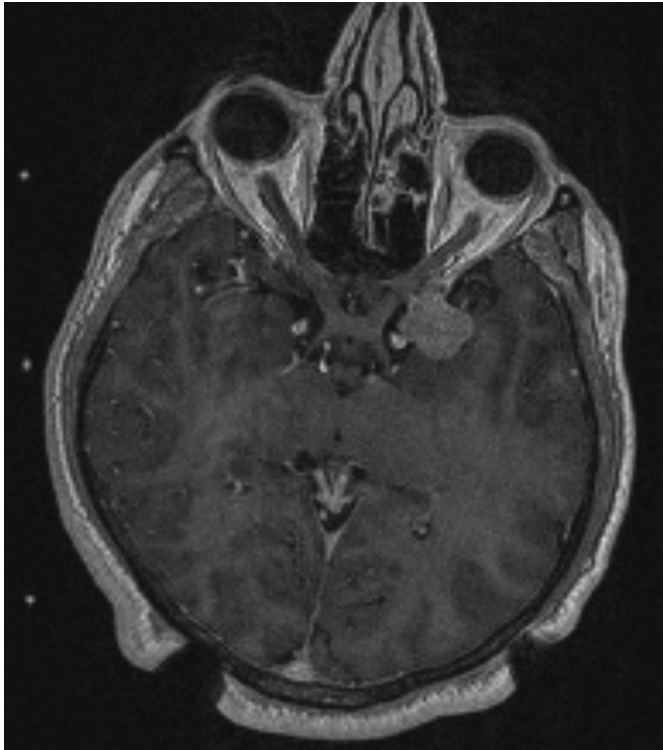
The axial 3D T1-weighted image, which used as an anatomic reference for treatment planning, shows the tumor and bilateral prechiasmatic parts of the optic nerves contoured to calculate the radiation dose received.
